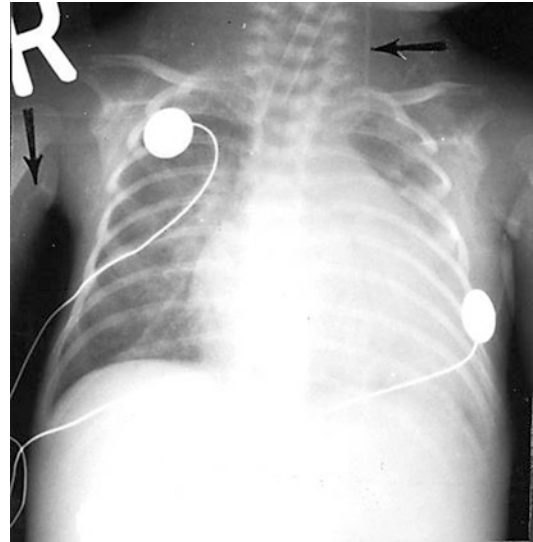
Radiograph examinations showed extensive vascular calcification extending down the upper and lower limbs, neck, supraclavicular fossae, and axillae. Radiograph here shows an enlarged heart and linear calcification (*arrows*) of the carotid and brachial arteries
